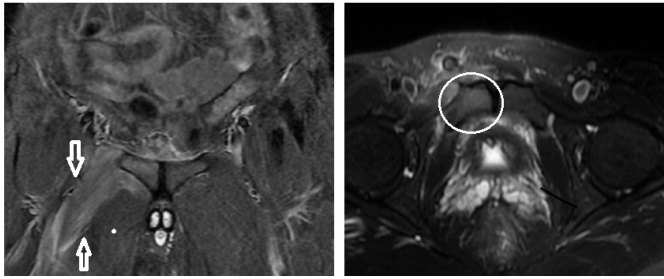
42 year-old male after inguinal hernia repair (TEP; without fixation and without slit); progressive right groin pain since 2nd day of the surgery. MRI scans at post-operative 10th day, demonstrate diffuse adductor muscle edema (arrows) with right pubic ramus osteitis (circle), possible nerve injury as a complication.
